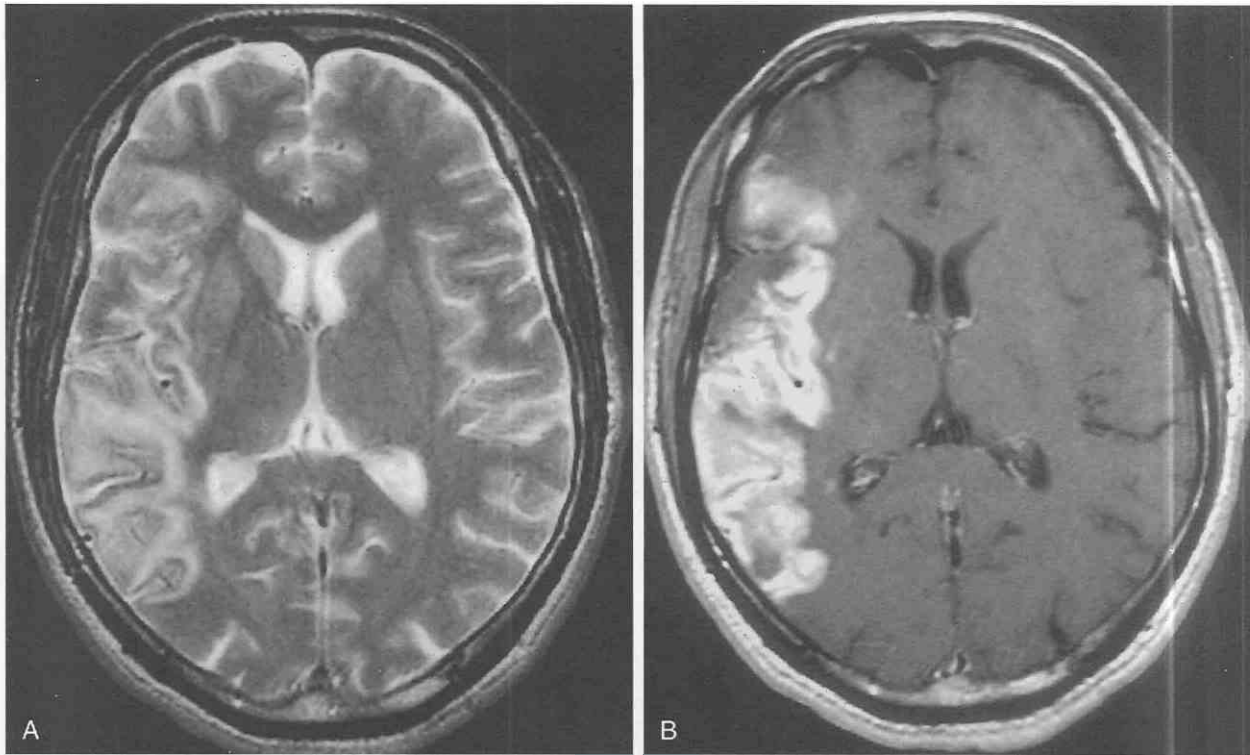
Enhancing infarction 1 week after symptom onset). *A*, T2-weighted axial image shows increased signal within the cortical territories of the right middle cerebral artery. *B*, T1-weighted axial image following intravenous gadolinium (0.1 mmol/kg) reveals gyral and subcortical enhancement. An enhancing infarct can often be differentiated from tumor by clinical information (e.g., acute onset of symptoms) and extent that conforms to the territory of a cerebral vessel.
